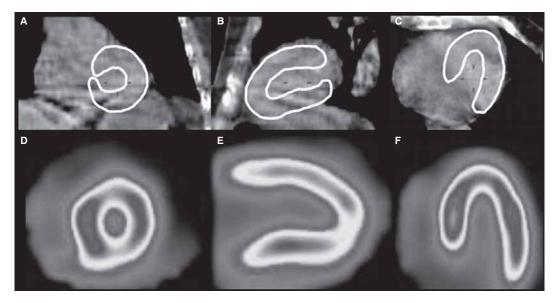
The same scintigrams as in Fig.4 after realignment of CT. A. Fused coronals; B. Fused sagittals; C. Fused transaxials; D. Attenuation corrected (AC) SPECT — short axis; E. AC SPECT — vertical axis; F. AC SPECT — horizontal axis.
